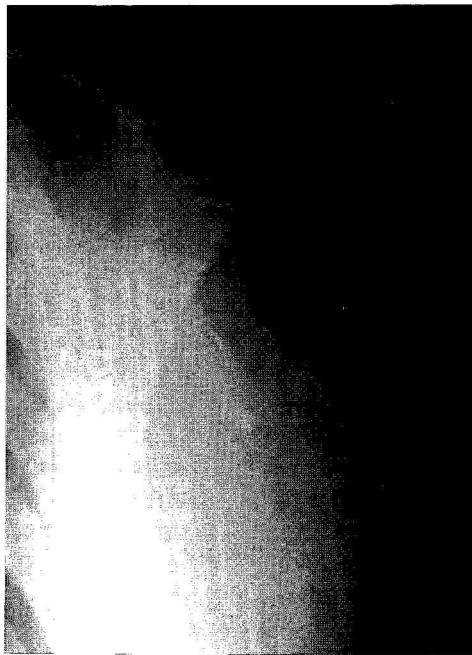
Anteroposterior radiograph showing the nitinol stent.
